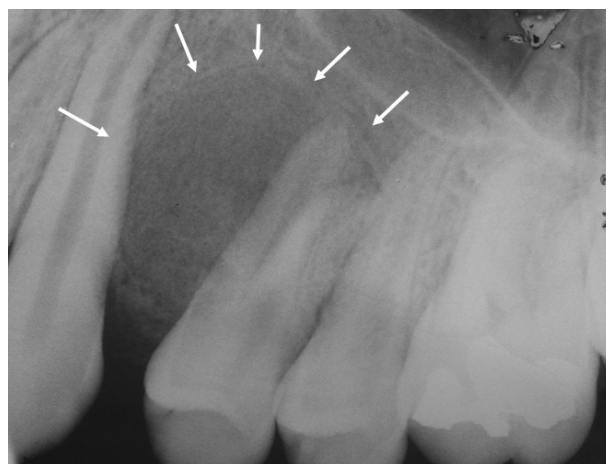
Well-delimited mixed radiographic image causing displacement of the involved teeth (case 2).
